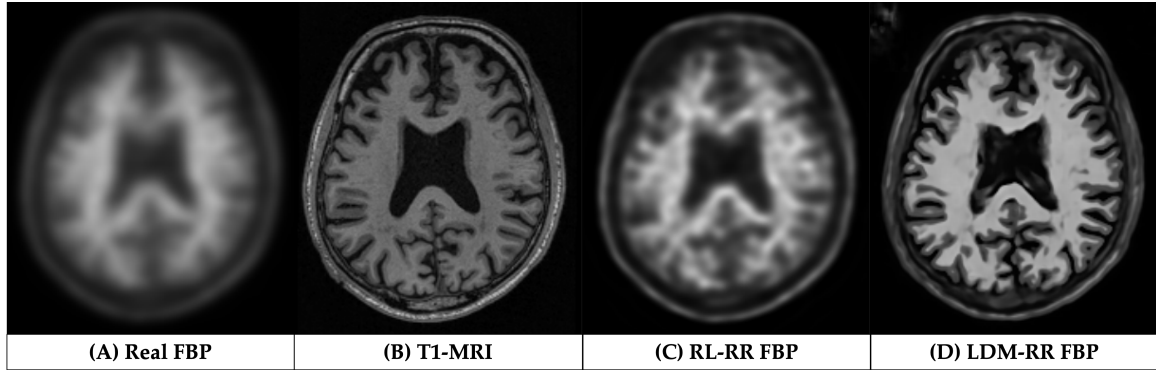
Visual Comparison of Generated FBP Scans Using RL-RR and Our LDM-RR to Real FBP and T1-MRI for a Sample from the OASIS-3 Cohort.
